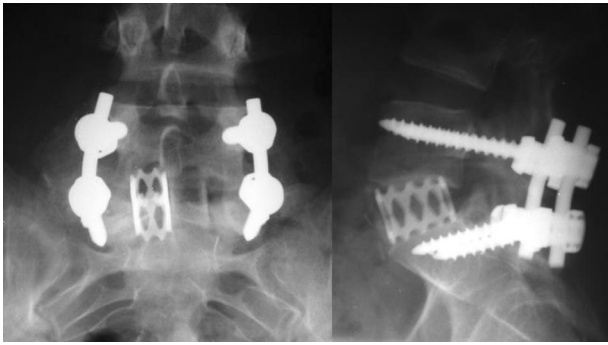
Postoperative plain radiographs indicate fusion by 5 months postsurgery.
